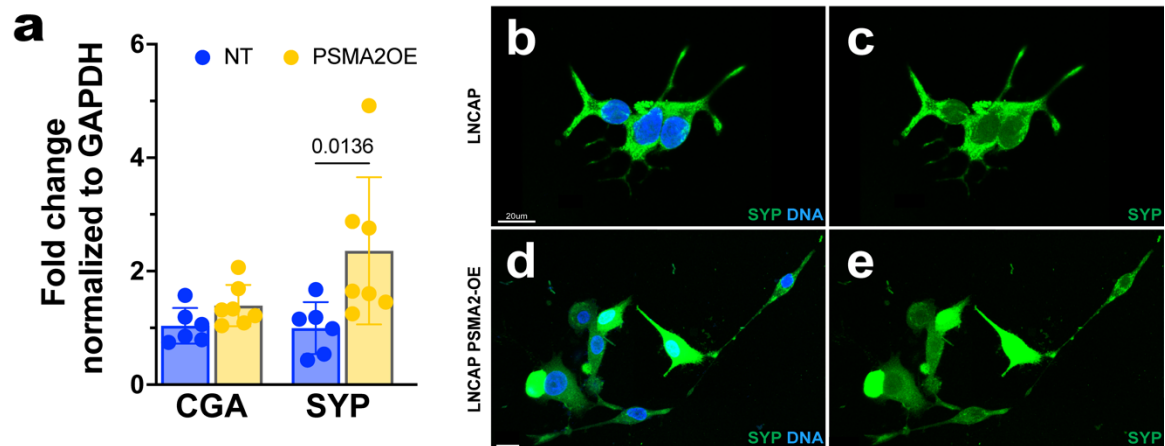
PSMA2 gain is Sufficient to promote NEPC fate transition.
